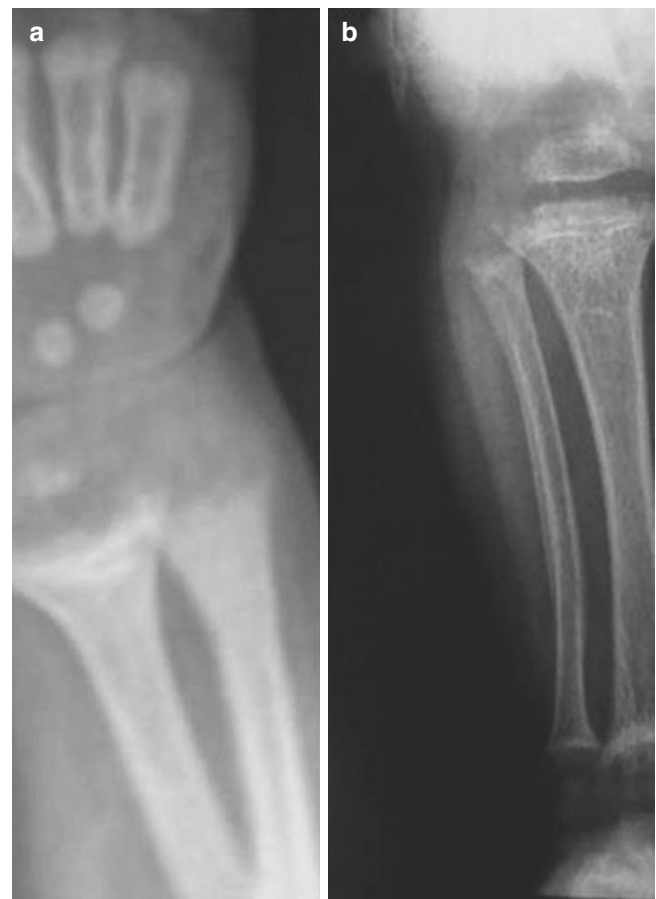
Radiographs of rickets. Radiographs of the wrist (a) and leg (b) of a 3-year-old boy with nutritional rickets showing the cupping, fraying, and widening of the physis
